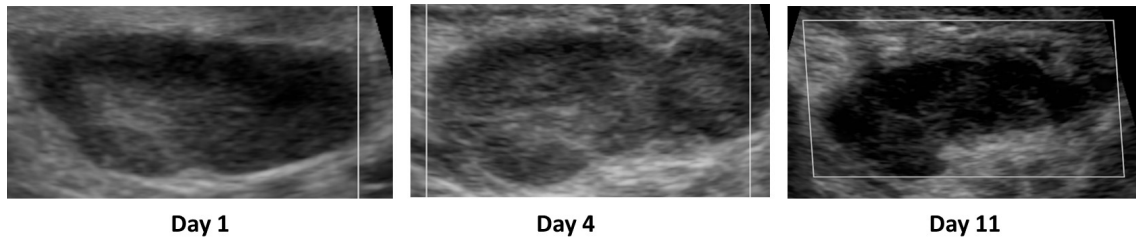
Ultrasound images taken on Day 1, Day 4 and Day 11 for case report #1
